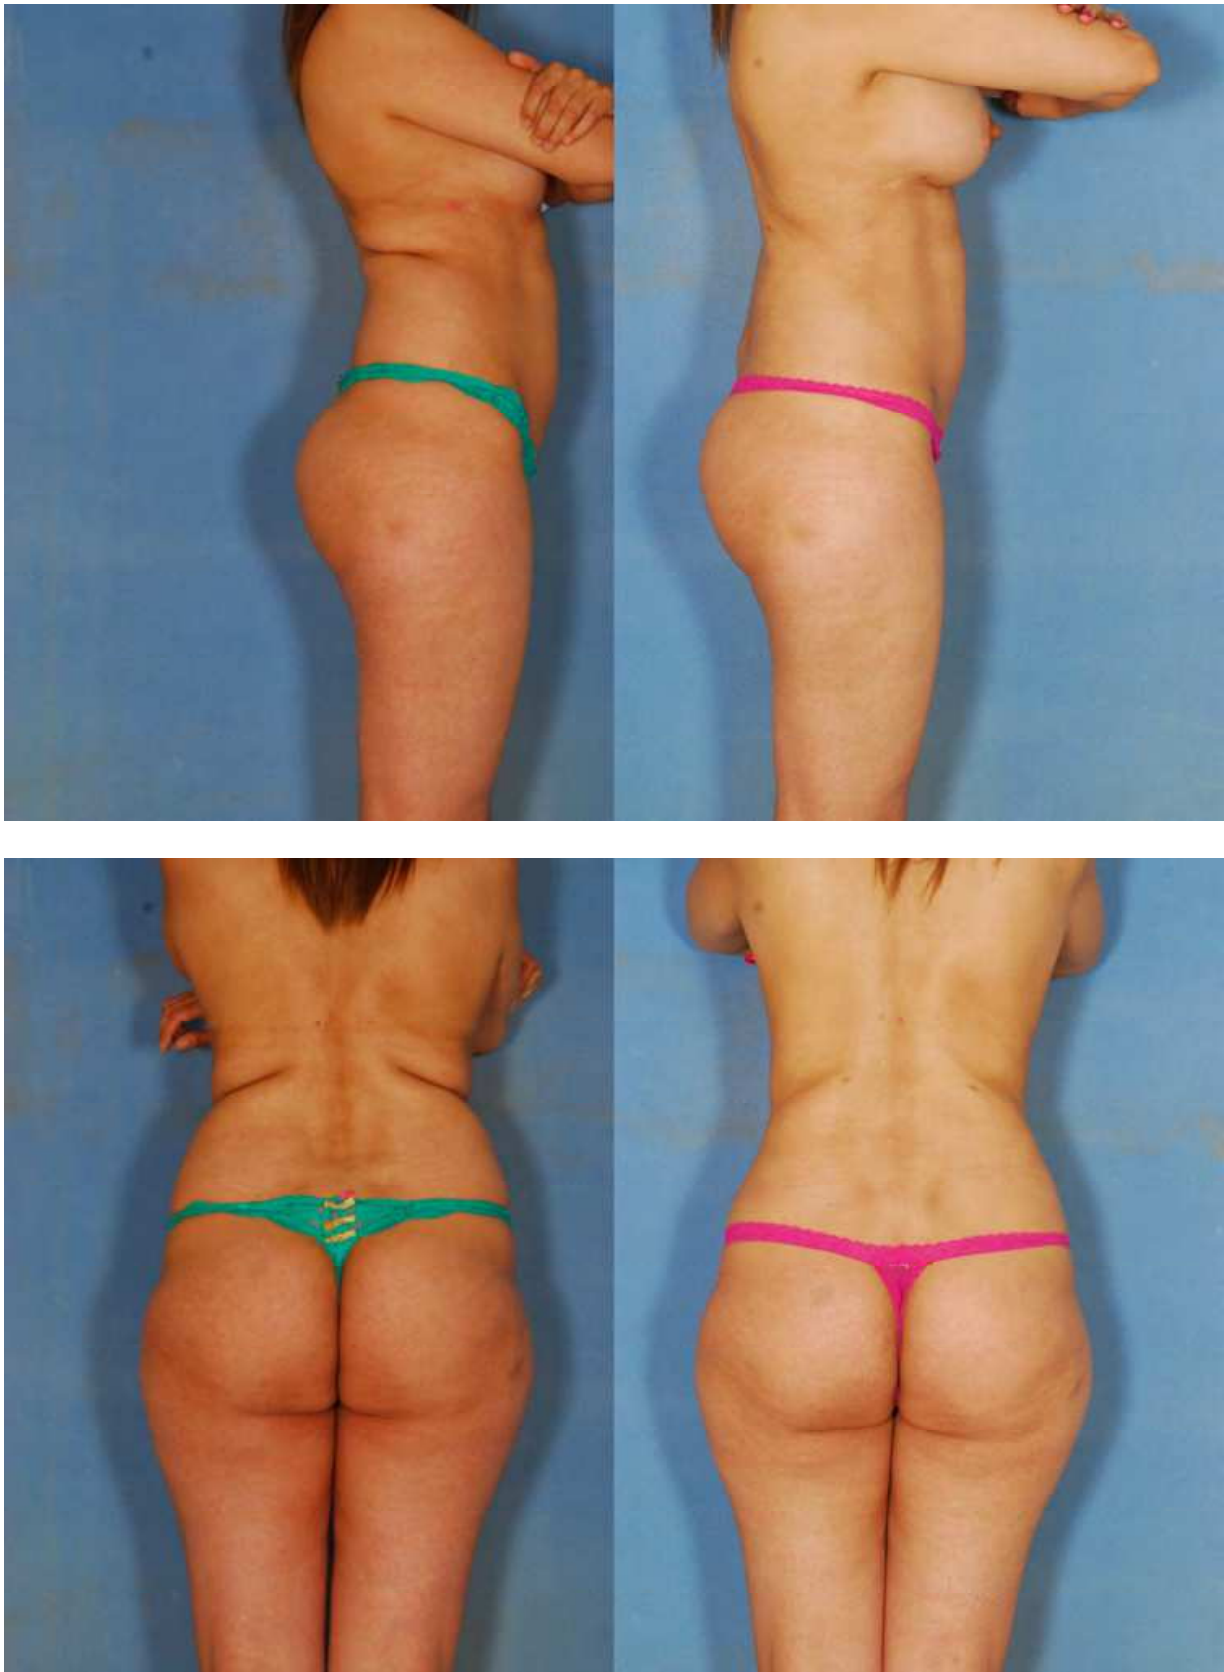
Ultrasound assisted liposuction of the back.
